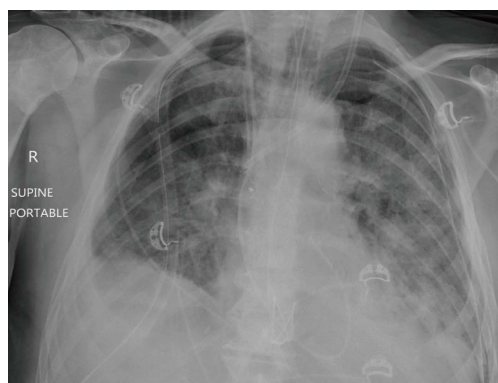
Chest X-ray of a 64-year-old male 3 d post transplantation showing reperfusion oedema. Bilateral airspace opacity predominantly in the mid to lower zones with associated bilateral pleural effusions.
